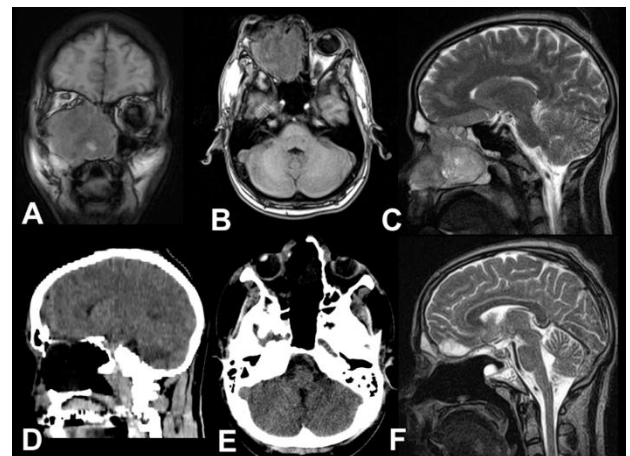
Preoperative and postoperative images. A: preoperative coronal T1 weighted image show the extensive lesion extended into the orbit. Hypointense margins apparently well definite correspond to the medial orbital wall and periorbita. B: preoperative axial T1 weighted image show the extension into the orbital compartment. C: preoperative sagittal T2 weighted image show the anterior cranial base infiltration (black arrow). D: 24 hours postoperative sagittal reconstruction of CT scan shows the extension of the resection and the absence of pneumoencephalus or other complications. E: 24 hours postoperative axial CT scan shows the removal the tumor and ocular globes in their normal position. F: 3 months postoperative sagittal T2 weighted image show the local control and the reconstruction of anterior cranial base (pericranium).
